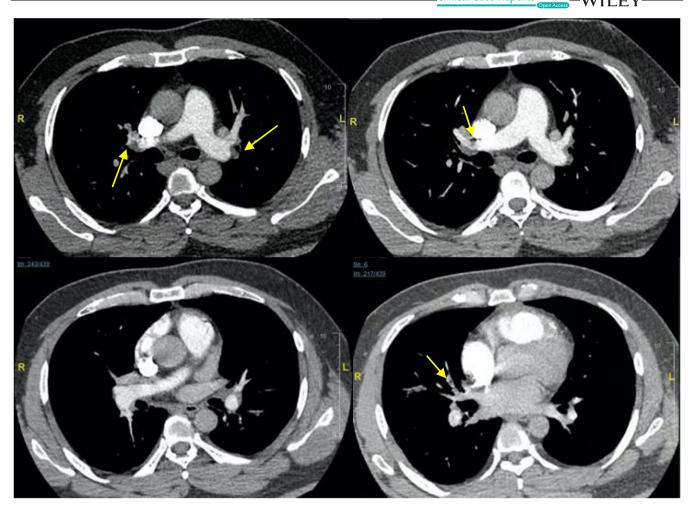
Computed tomography angiography of the pulmonary artery (CTPA) after 2 weeks: a significant size reduction of emboli in the bilateral pulmonary arteries, yellow arrow
